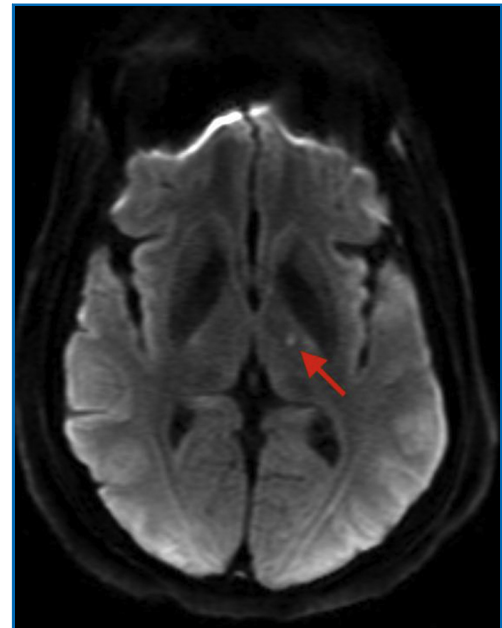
Postoperative diffusion-weighted image showing the smaller than optimal cytotoxic lesion generated by the focused ultrasound treatment (arrow).
